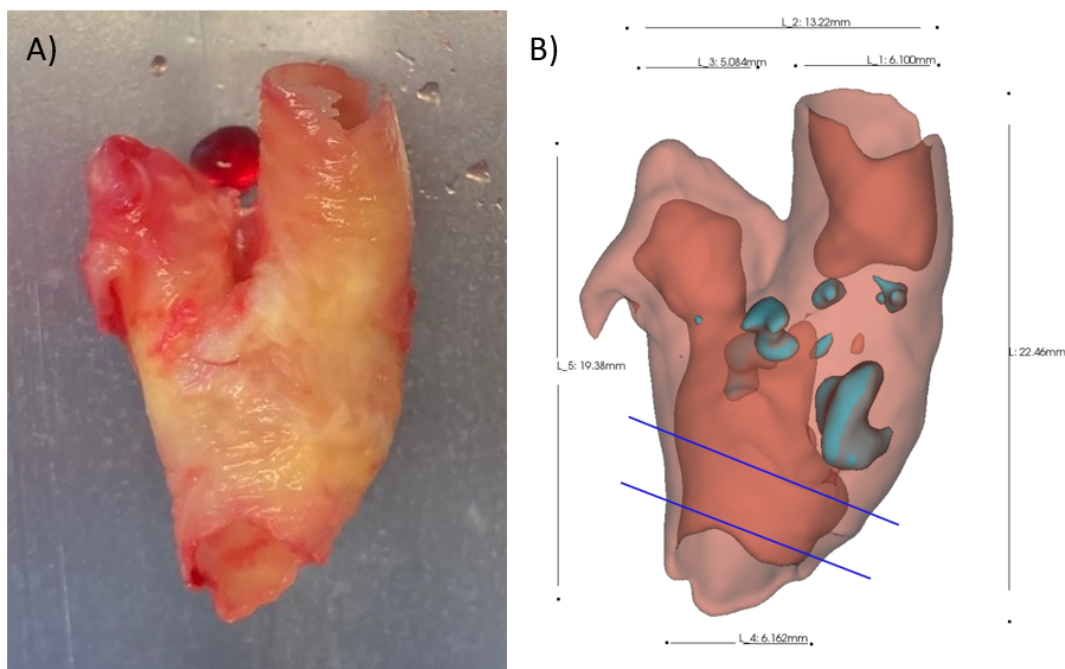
A) CEA sample on the μ CT platform before imaging. B) Reconstructed μ CT scan showing non-calcified tissue (red) and calcified constituents (light blue) and their dimensions. The blue lines enclose the area to provide the location of the strips obtained.
